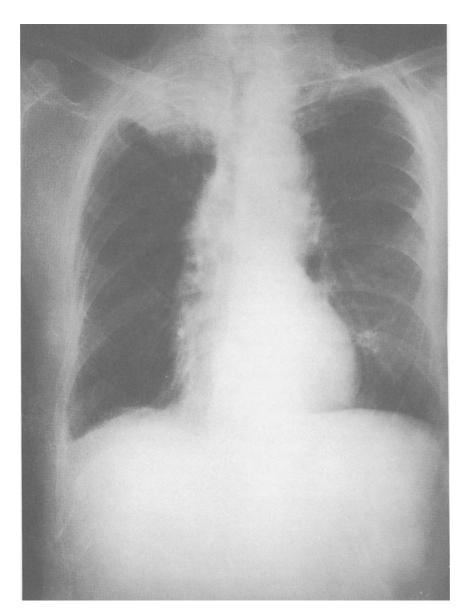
Right upper lobe reactivation TB with right hilar adenopathy subsequently found to be a lung carcinoma. Radiograph courtesy of Maimonides Medical Center Radiology Department.
